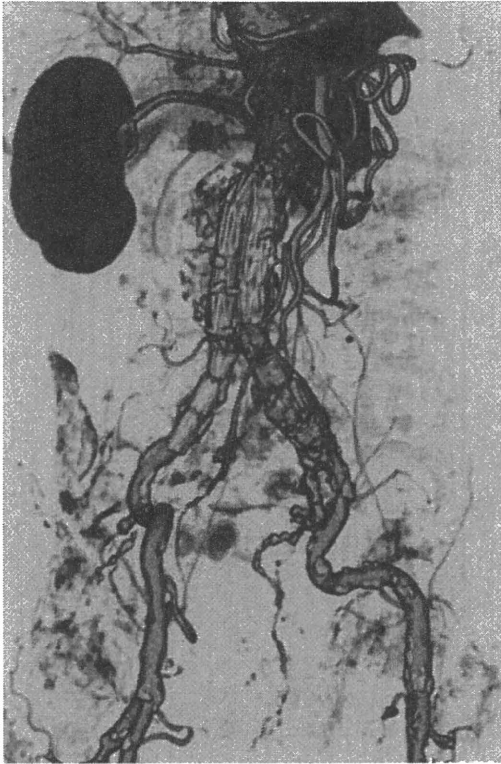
Preoperative three-dimensional computed tomography (3D-CT) scan revealed no evidence of severe tortuosity of the right graft limb
